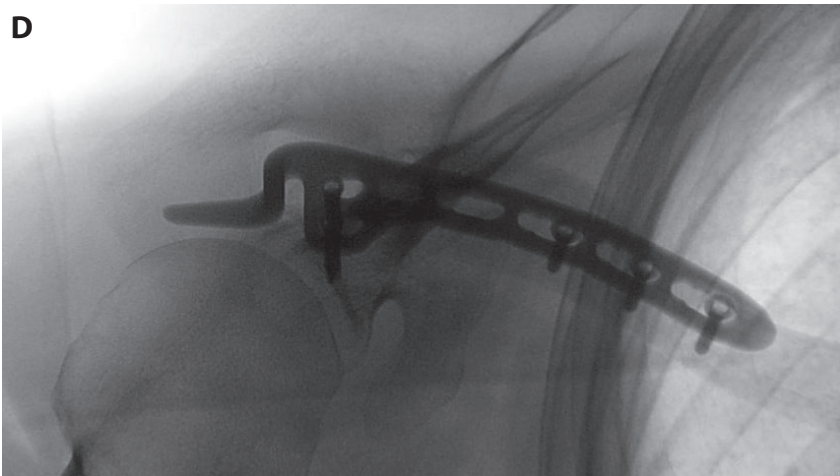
AND 5D. Intraoperative x-rays of open reduction and internal fixation with 3.5 LCP hook plate (DePuy Synthes, Switzerland) in a bridging technique through a longitudinal approach.
